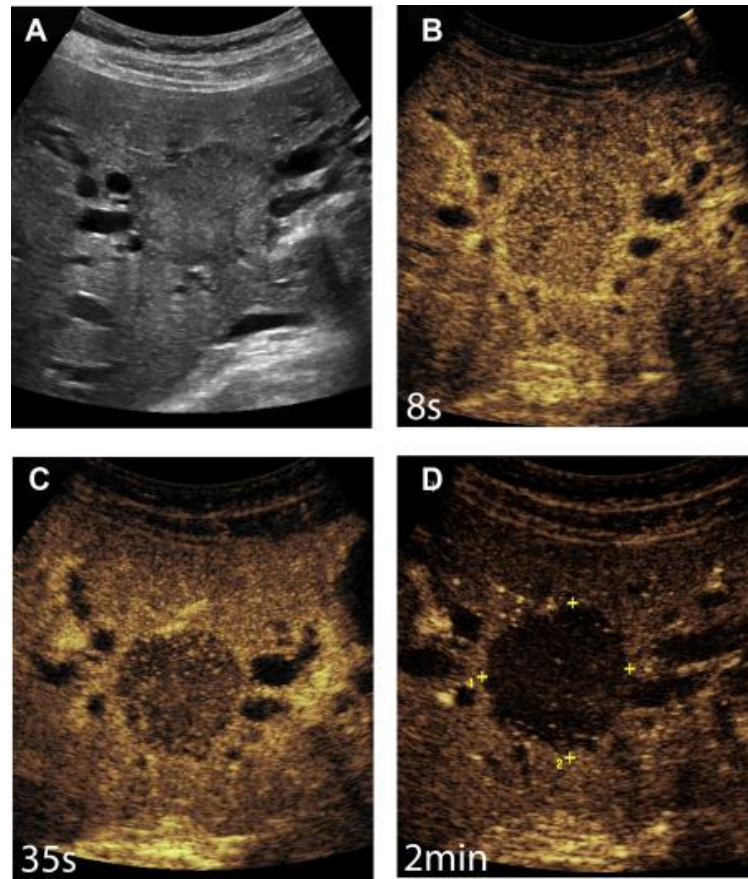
Sonograms using MB contrast agents a) traditional gray-scale image with no MB contrast agent, b) the image 8 seconds after administration of MBs, c) the image 35 seconds after MB administration and d) the image 2 min after MB administration. (Reproduced from [185])
